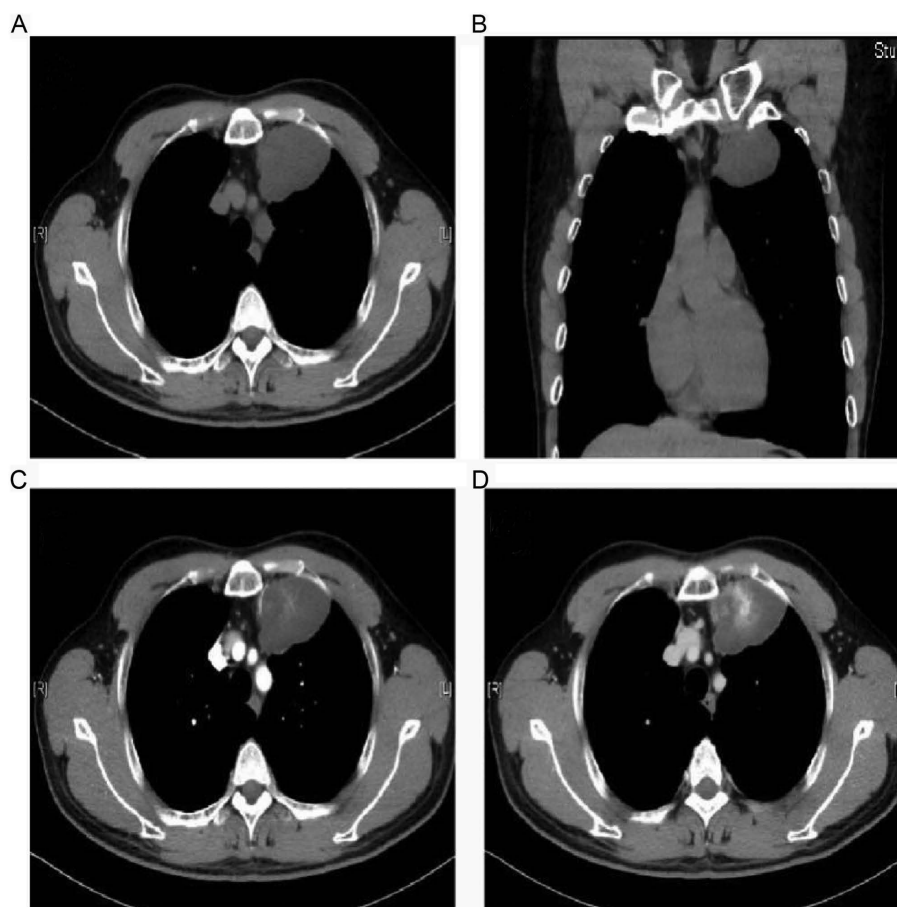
Case 3. (A and B) Radiological features of thoracic dendritic fibromyxolipoma on CT imaging. CT demonstrated a homogenous low-density shadow in the left thoracic cavity attaching to the anterior chest wall. It measured 43x60x36 mm with a well-defined boundary and was heterogeneously enhanced. The tumor center was enhanced more markedly in the (D) venous phase than the (C) arterial phase.
